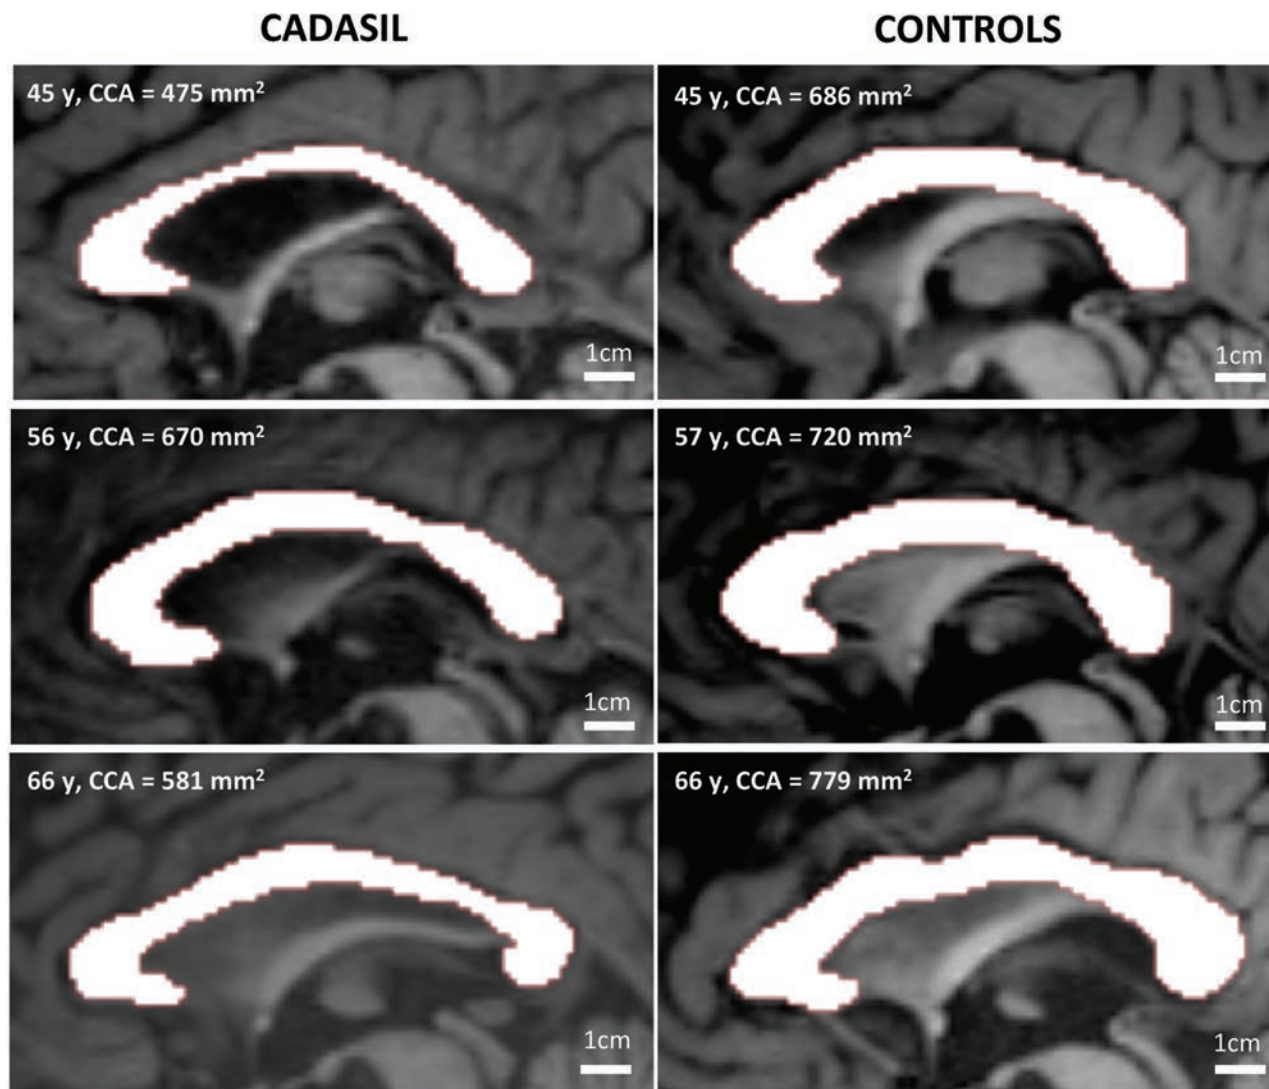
Examples of corpus callosum area delineation in 3 patients with CADASIL and 3 age-matched controls. Reproduction at the same scale of noninterpolated midsagittal T1-weighted images of the corpus callosum in 3 patients (*left column*) compared with 3 age-matched controls (*right column*). Corpus callosum atrophy appears obvious in some cases.
